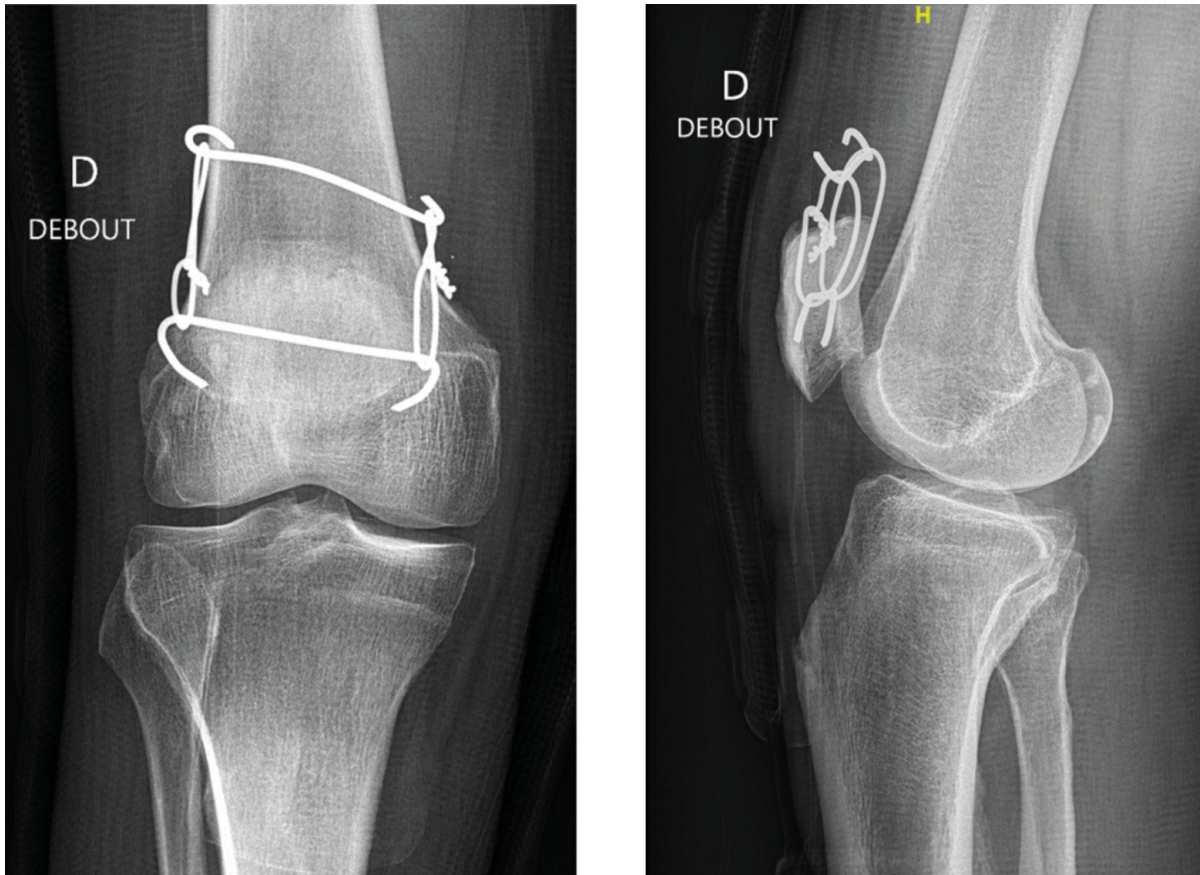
Postoperative x-rays.
